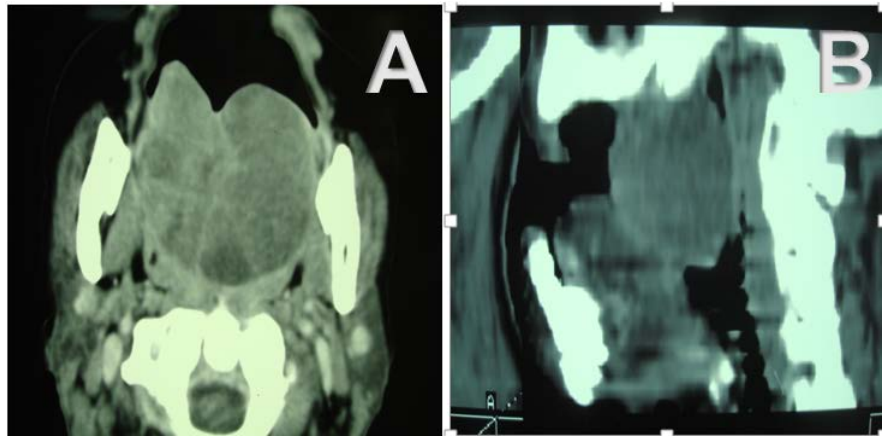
CT scan of the facial area in axial; (A) and sagittal; (B) sections showing a well-circumscribed tumor of the posterior palate with obstruction of the oropharyngeal canal.
